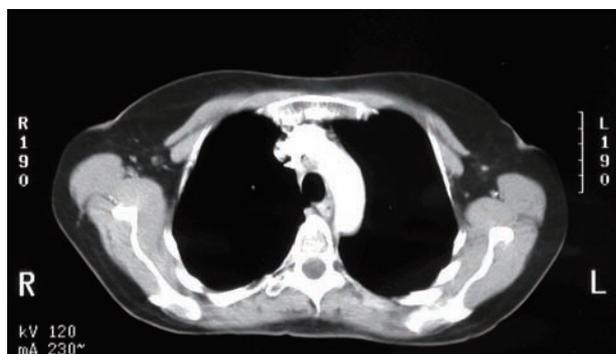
On postinduction chest CT there was a complete radiological response in the mediastinum
